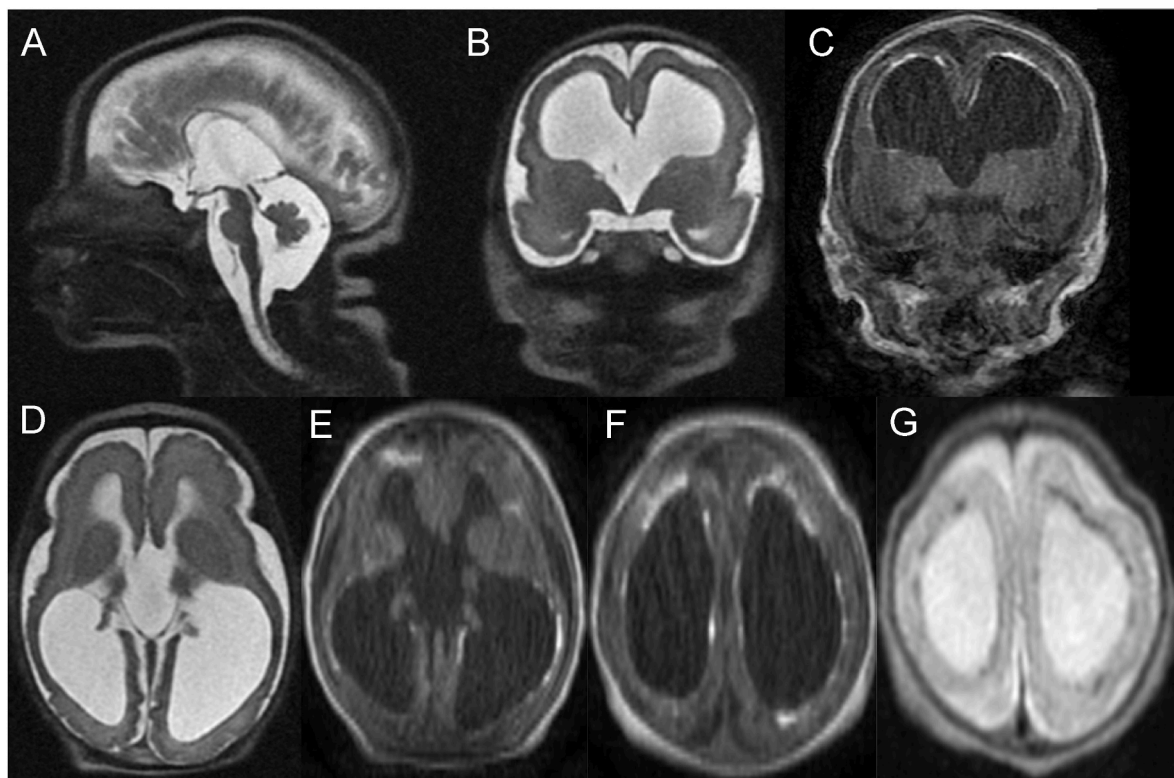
(Case 2) Neonatal brain MRI at 6 days of age of infant diagnosed with congenital CMV (A: sagittal T2 sequence showing microcephaly, thinning of corpus callosum and small posterior fossa structures; B–C: coronal T2 (B) and T1 (C) sequences showing abnormal cortical gyration, enlarged opercula, perisylvian polymicrogyria, ventriculomegaly, and white matter volume loss; D–E: axial T2 (D) and T1 (E) sequences showing similar findings to D and E; F–G: axial T1 (F) and modified T2 (G) sequences showing ventriculomegaly and periventricular calcifications).
